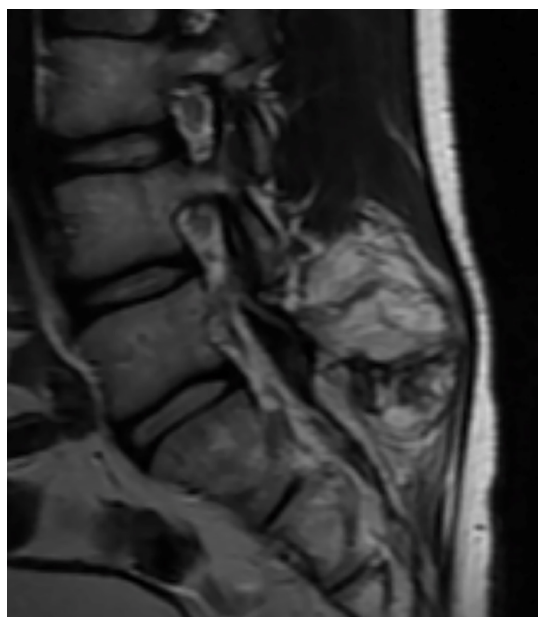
Sagittal T2 magnetic resonance image demonstrating the well-defined 1.5 cm cartilaginous cap of the lumbar osteochondroma extending into the right paraspinal musculature.
